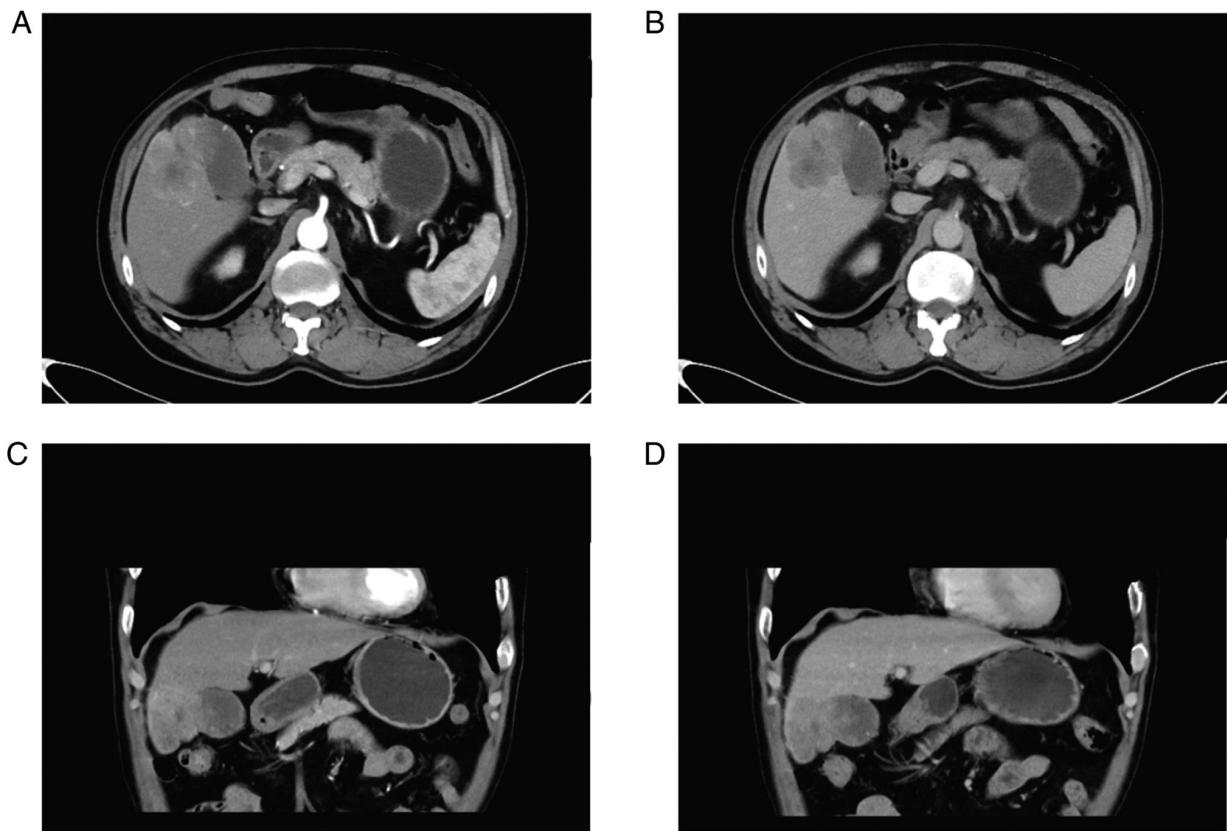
CT images of case 1. (A) Cross-sectional contrast-enhanced arterial phase CT of the abdomen. (B) Cross-sectional contrast-enhanced venous phase CT of the abdomen. (C) Contrast enhanced arterial phase CT scan of the abdomen, coronal view. (D) Contrast enhanced arterial phase CT scan of the abdomen, coronal view. CT, computed tomography.
